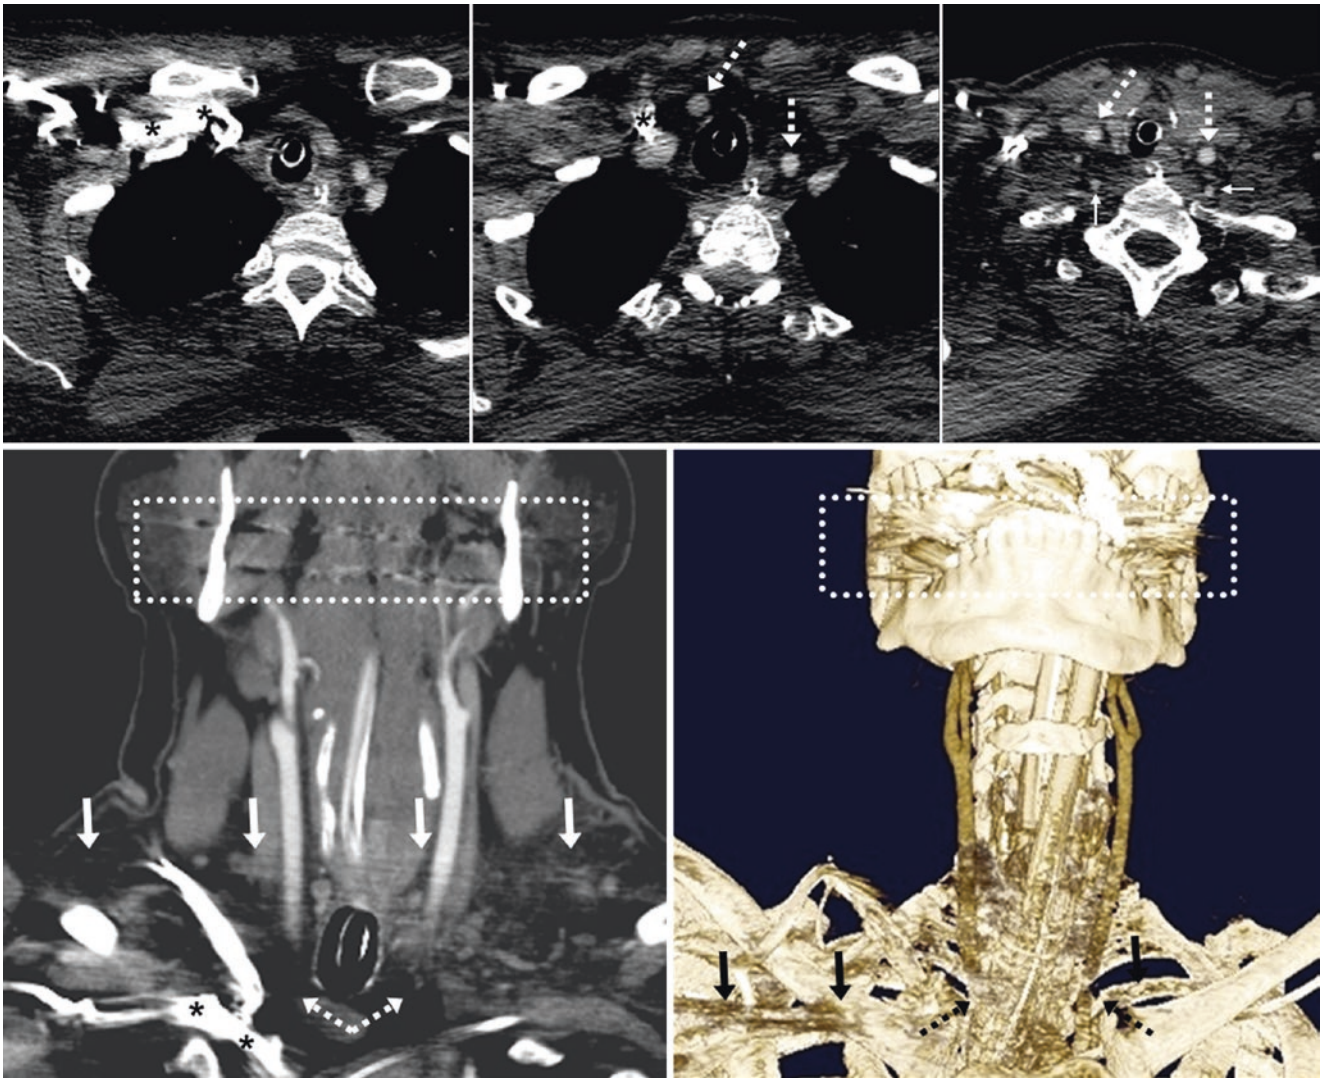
43-year-old with shoulder streak artifact. *Top row:* on neck CTA axial images, severe streak artifact from both shoulders, along with contrast persistence within the right BCV and SCLV (*asterisks*), together combine to completely obscure the lower CCAs (*dotted*
